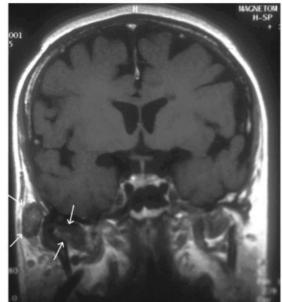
(A) Case 2: MRI Axial. (B) Case 2: MRI Coronal.
